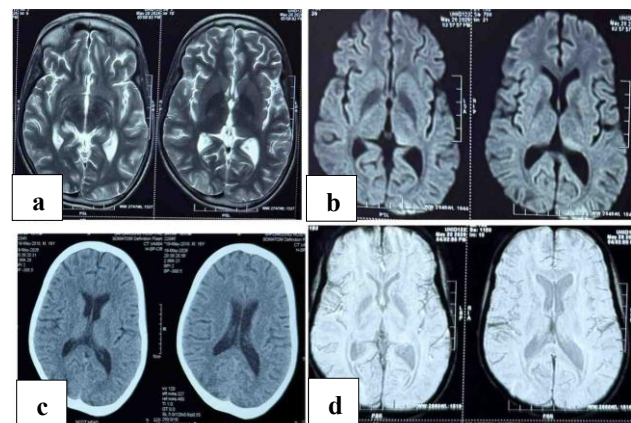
MRI brain showing features of typical PRES; (a and b) parietooccipital white matter T2 and FLAIR hyperintensities, (c) parietooccipital hypoattenuation, and (d) normal SWI.
